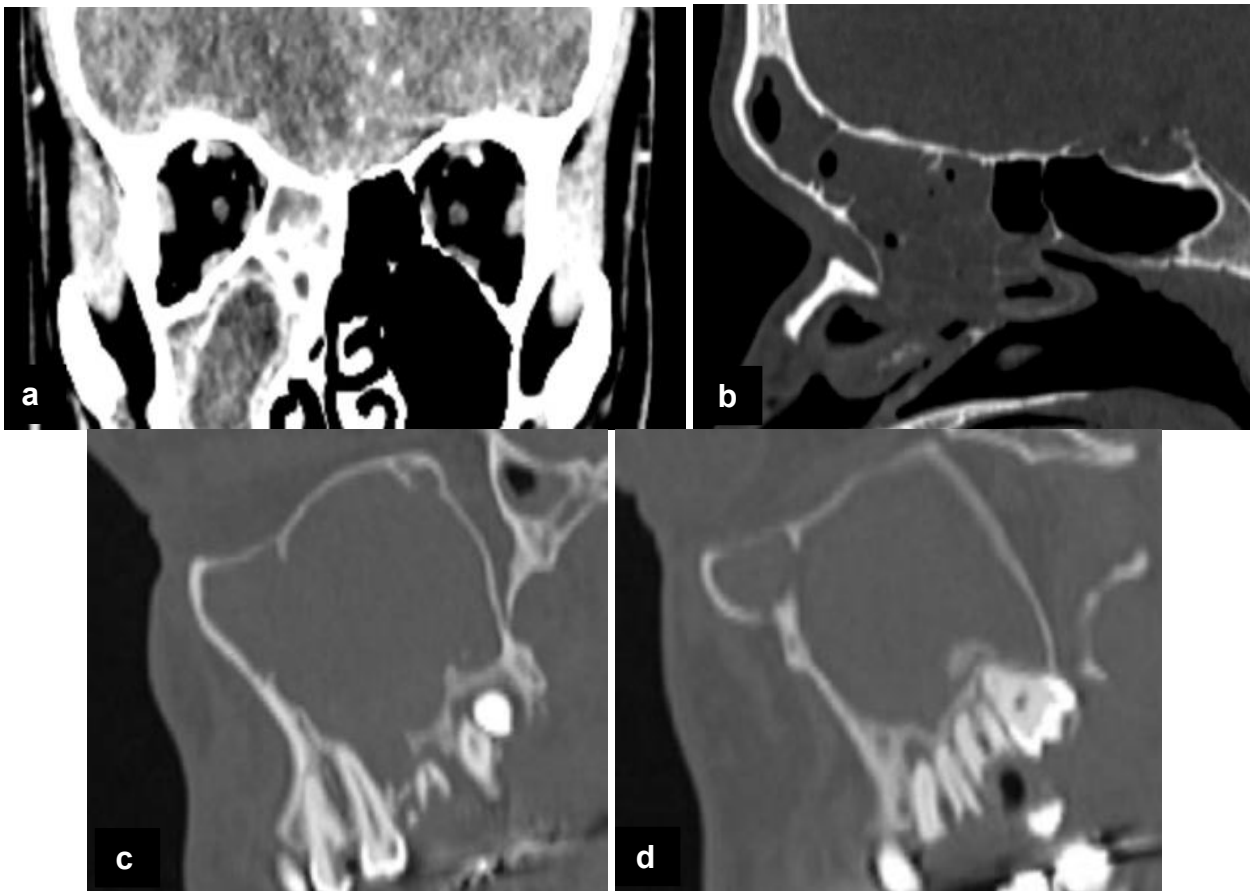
CT showing the unilateral inflammatory content in paranasal sinuses (a), opacification of right maxillary sinus and anterior ethmoid cells (b), opacified right maxillary sinus (c, d) with a floor defect adjacent to periapical process of tooth 16 (c), deep cavities of teeth 16 and 17 with periapical processes (d).
